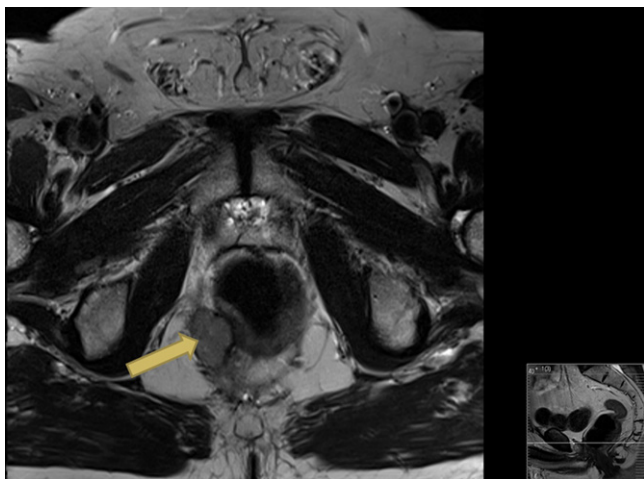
MRI pelvis. Arrow indicates perirectal mass.
